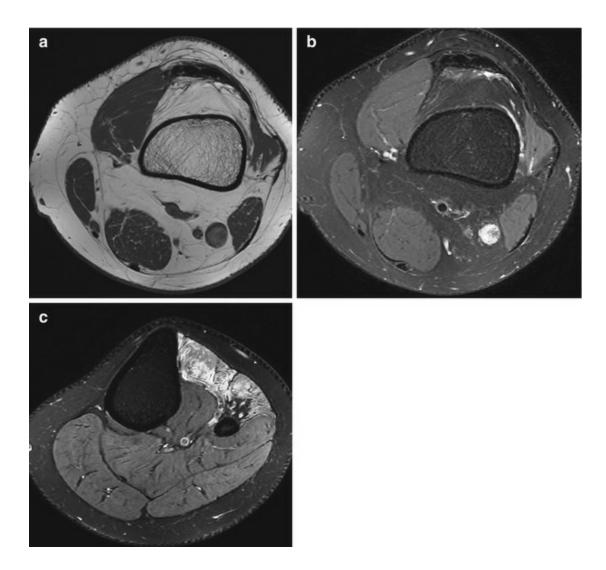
A 26-year-old soccer player with a hematoma of the common peroneal nerve after a knee trauma. Axial (a) T1- and (b) fat-suppressed T2-weighted MRI show an enlargement of the common peroneal nerve with a loss of the fascicular structure, above the level of fibular head. (c) Axial fat-suppressed T2-weighted MRI shows patchy high signal in tibialis anterior, extensor digitorum, extensor hallucis longus muscles
